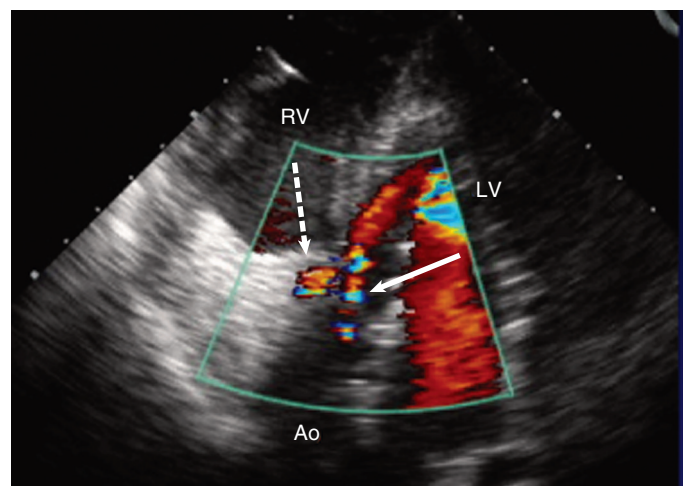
Deep transgastric transesophageal view of a balloon-expandable aortic prosthesis with paravalvular (dotted arrow) and valvular (solid arrow) regurgitation. Ao = aorta; LV = left ventricle; RV = right ventricle.
